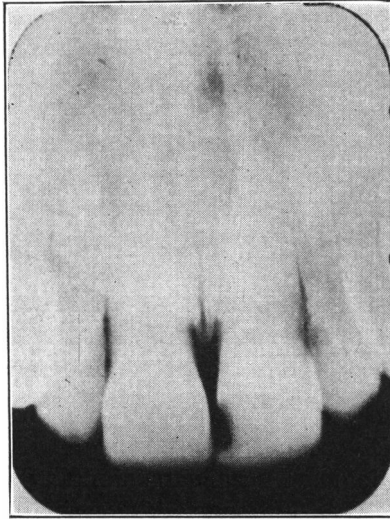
X-ray of two central incisor teeth which shows that saliva, food retention, and bacteria cannot be the only factors in the cause of dental caries, as only one of the two closely adjoining tooth surfaces has become carious.
